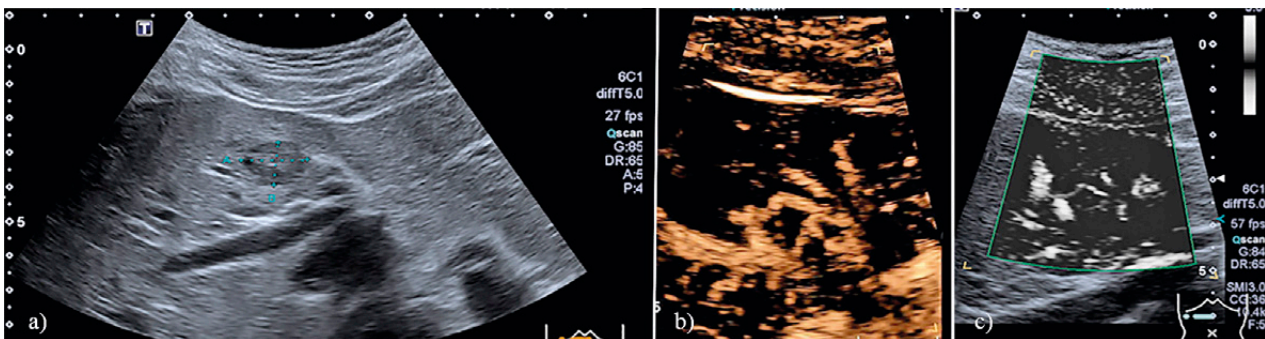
A 25-year-old woman who presented with suspected autoimmune pancreatitis. Pancreas-MRI incidentally showed an FLL of 1.8 cm of unclear dignity. SOR was CEUS with a of 18-month follow-up. B-mode Ultrasound showing 1.8 cm FNH (a), CEUS with arterial spoke-wheel enhancement(b) and SMI with spoke-wheel pattern (c).
